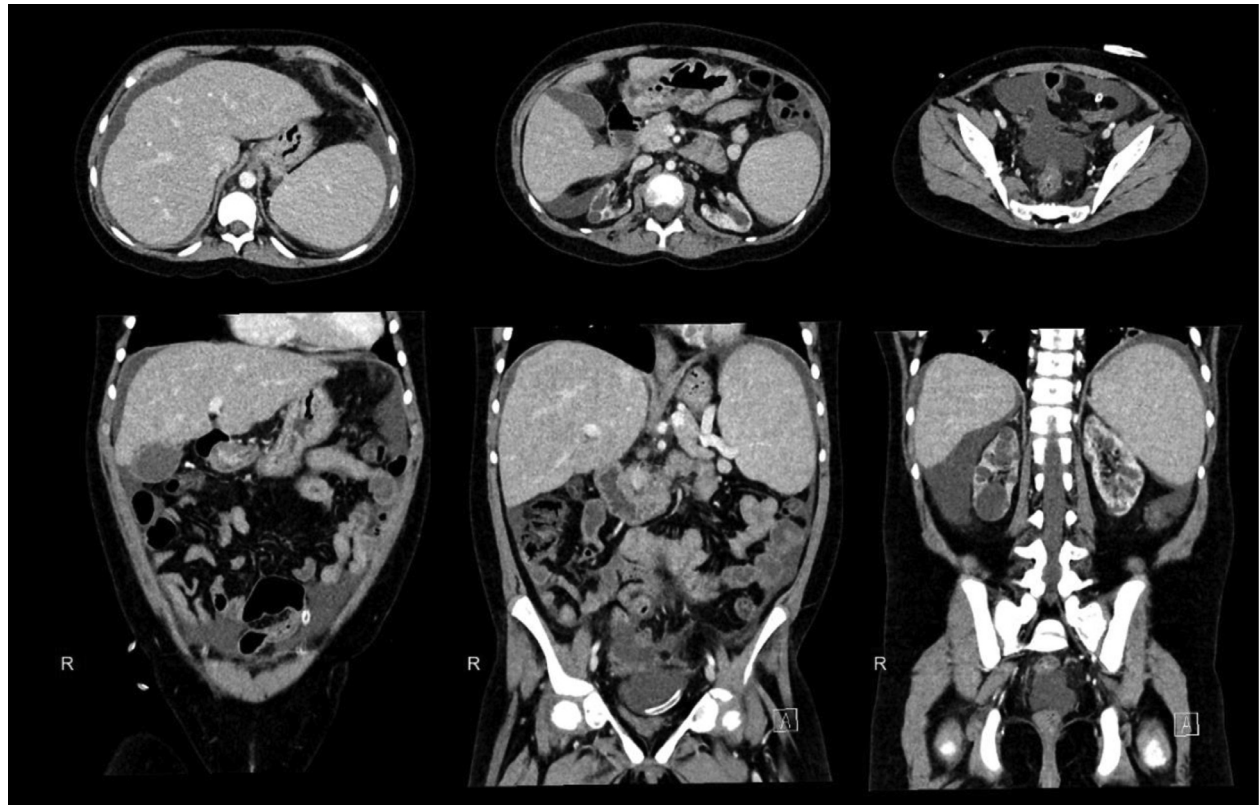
Axial and coronal computed tomography (CT) images of the abdomen and pelvis 2.5 years prior to presentation show normal spread-out bowel loops without bowel wall thickening or peritoneal calcifications. Small volume peritoneal fluid with peritoneal dialysis catheter tubing in the lower abdomen are again noted.
